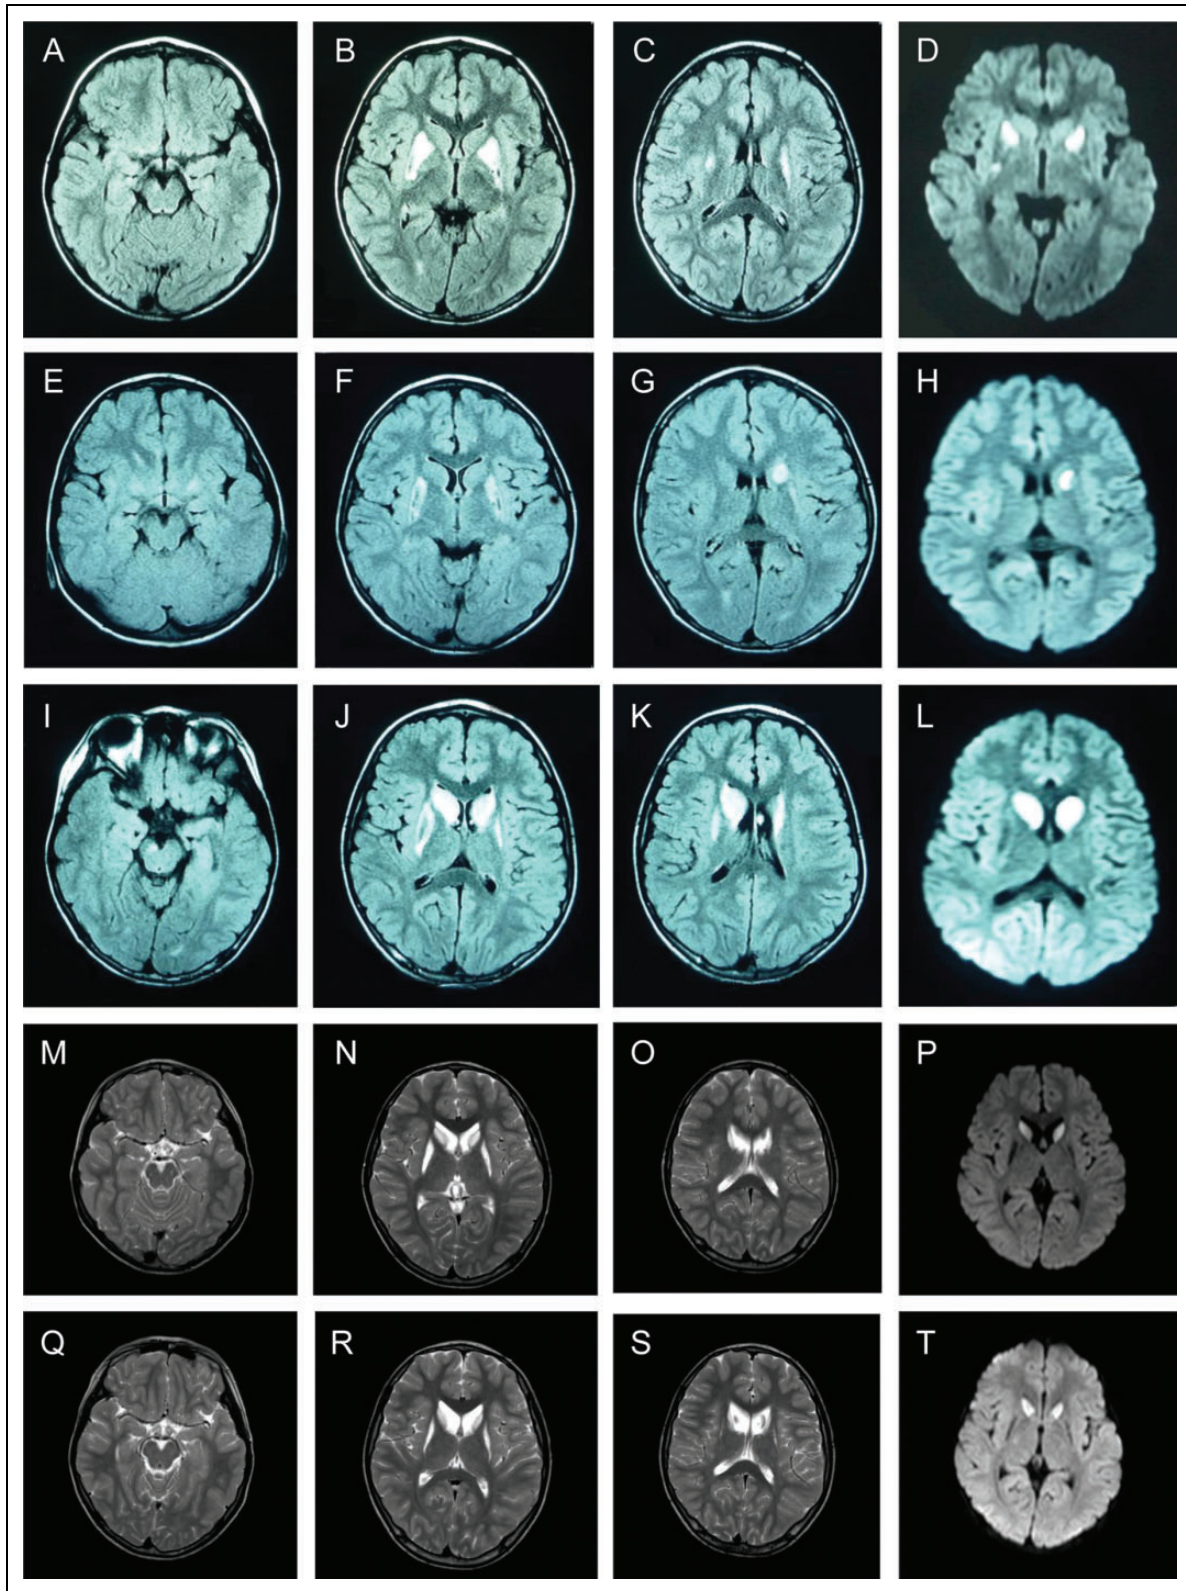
A-D, Brain magnetic resonance imaging (MRI) obtained at 3 years 2 months of age shows high signal intensity lesions with partially cystic lesions in the bilateral putamina on fluid-attenuated inversion recovery images (A-C) and diffusion diffusion-weighted imaging (D). E-H, Brain MRI obtained at 5 years 2 months of age show a high signal intensity lesion that is newly detected in the left caudate nucleus on fluid-attenuated inversion recovery images (E-G). Diffusion-weighted imaging shows that the bilateral putamina are iso- or hypointense and the left caudate nucleus is hyperintense (H). I-L, Brain MRI obtained at 6 years 11 months of age shows high signal intensity lesions spread to bilateral caudate nuclei and the midbrain (right substantia nigra) on fluid-attenuated inversion recovery images (I-K) and diffusion-weighted imaging (L), in addition to the putaminal hyperintensities. M-O, Brain MRI obtained at 8 years 6 months of age shows high signal intensity lesions in the bilateral putamina and caudate nuclei on T2-weighted (M-O) and diffusion-weighted imaging (P). Q-T, Brain MRI obtained at 10 years 5 months of age shows high signal intensity lesions in the bilateral putamina and caudate nuclei on T2-weighted (Q-S) and diffusion-weighted imaging (T). There is a trend for decrease in striatal volume. A-C, E-G, I-K: fluid-attenuated inversion recovery images; M-O, Q-S: T2-weighted images; and D, H, L, P, T: diffusion-weighted images.
